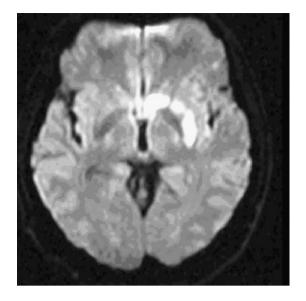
Magnetic resonance image shows infarction in the territory of left middle cerebral artery.
